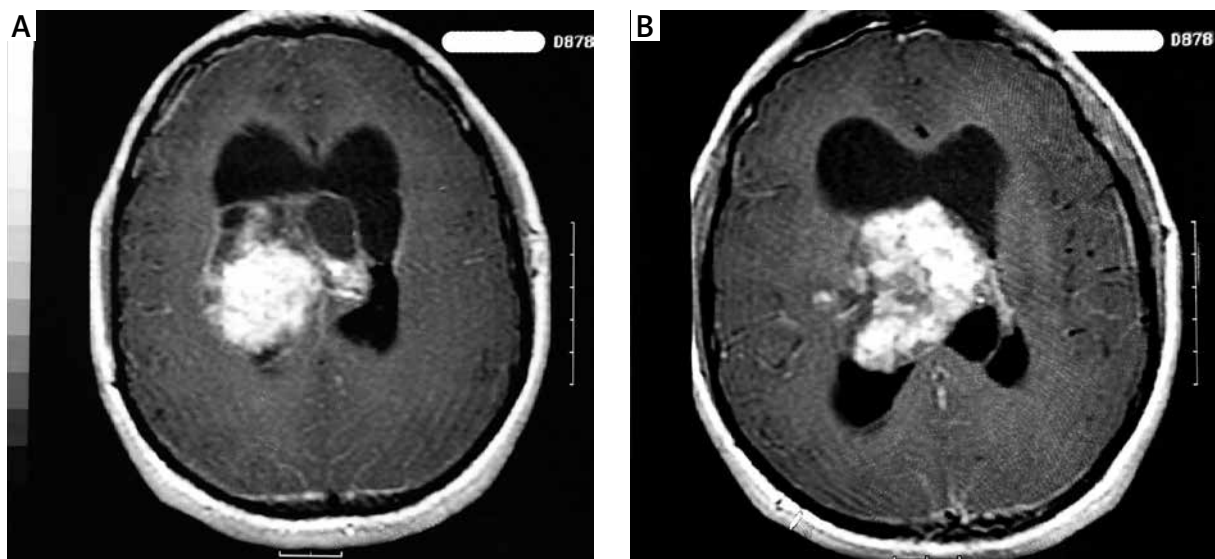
On T1-weighted MRI showed a large, partly cystic, 4 × 5 cm mass in the third ventricle with heterogeneous enhancement with gadolinium.
